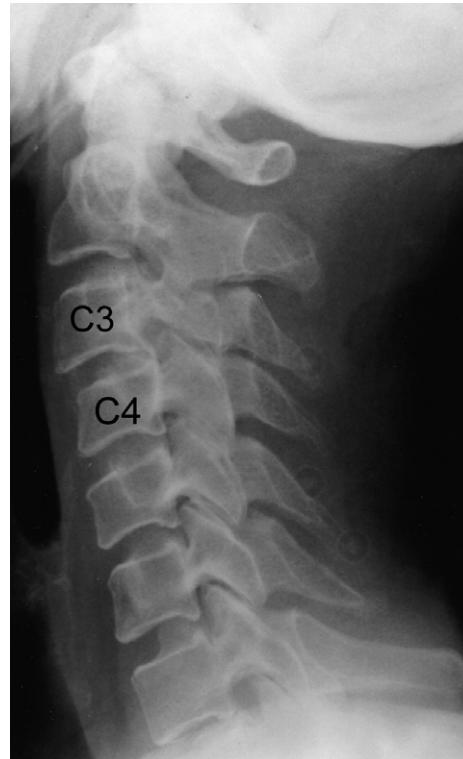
Cervical spine lateral plain X-ray image taken soon after the motor vehicle accident. Note the loss of normal cervical spine contour and the fixed anterolisthesis of C3 on C4, measuring approximately 4 mm. In addition, the height of the C3 articular pillars appeared to be decreased.
